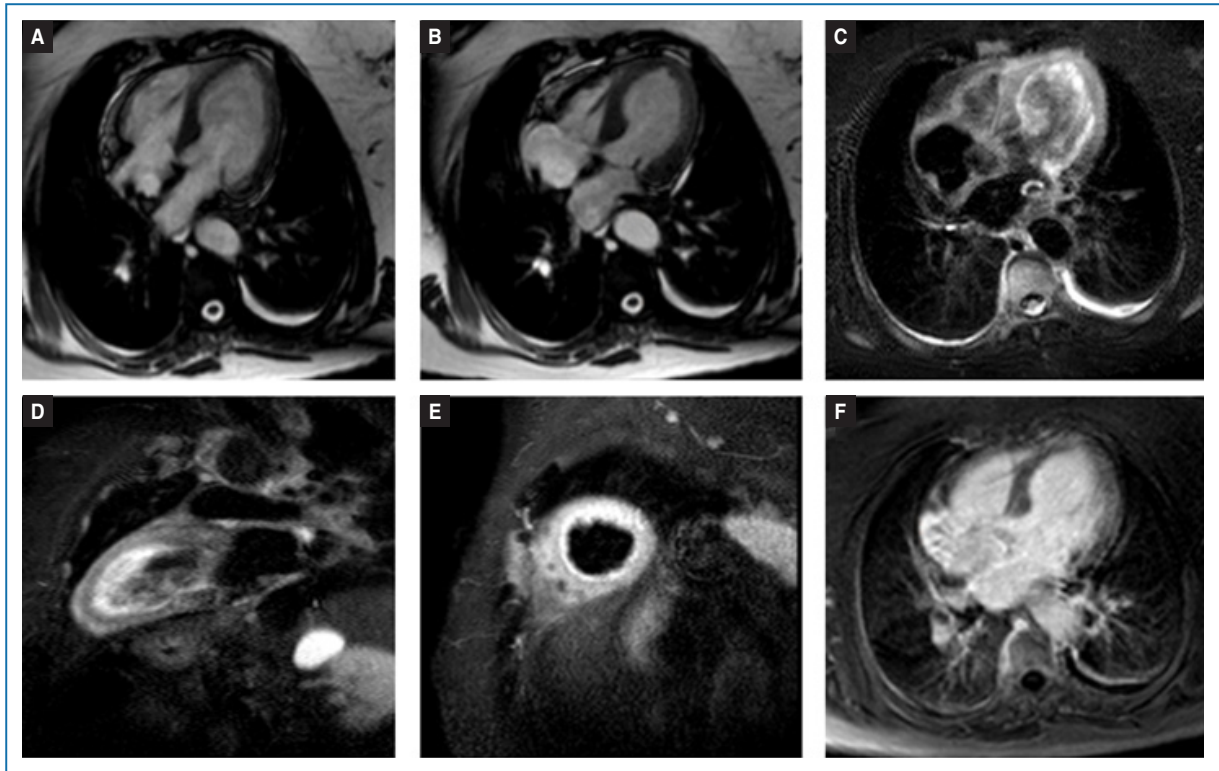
Cardiac magnetic resonance (MR) imaging performed on admission. Four-chamber cardiac MR cine frame in end-diastole and end-systole A and B: showing circumferential hypokinesia of apical and midventricular segments. C: T2-weighted short inversion time inversion recovery images of four-chamber and D and E: the long and short 2 chamber views, showing diffuse increase of myocardial signal (edema) in the hypokinetic segments. F: No late gadolinium enhancement was detected in the affected segments in the gadolinium-enhanced T1-weighted MR sequences.
